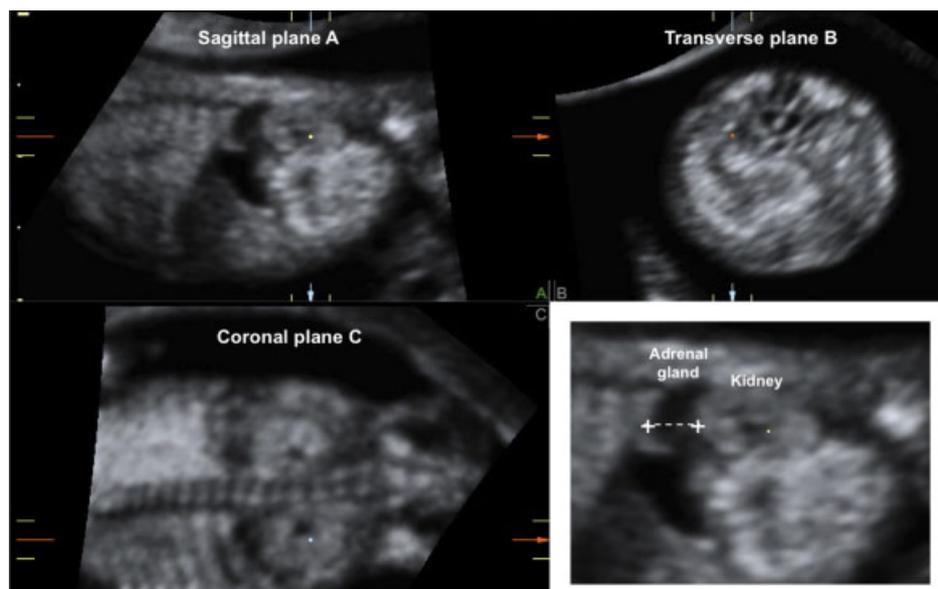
Measurement of the adrenal gland length using three-dimensional ultrasound
